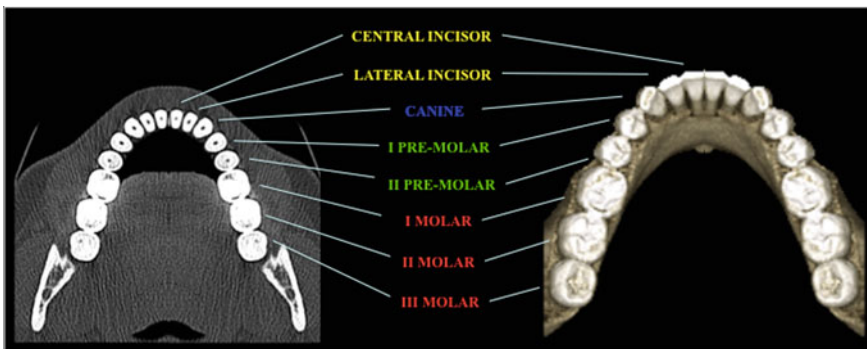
Permanent teeth. *Left* axial CBCT scan indicating every single dental units; *Right* corresponding 3D-CBCT reconstruction
